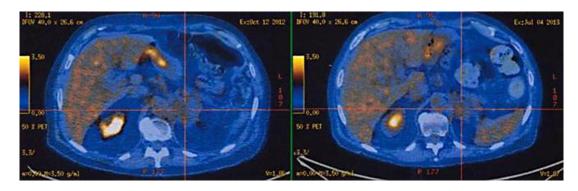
Documentation of radiotherapy response between by comparing the 18 F-FDG PET-CT scans from October 2012 (left panel) and July 2013 (right panel).
